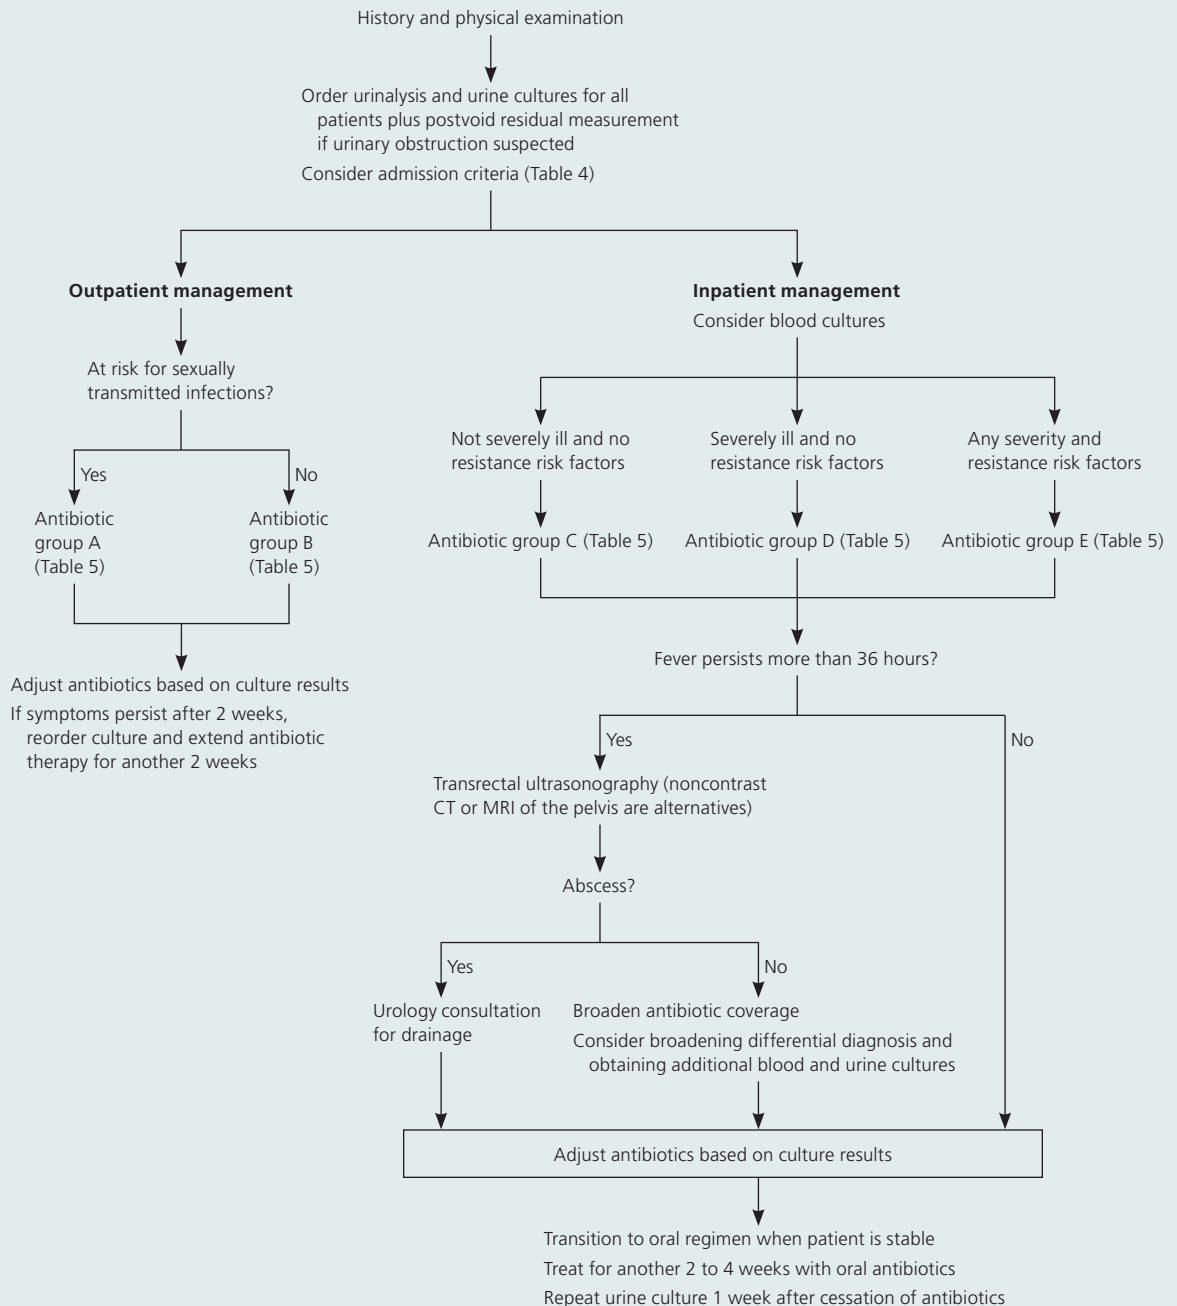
Management of acute bacterial prostatitis. (CT = computed tomography; MRI = magnetic resonance imaging.)
